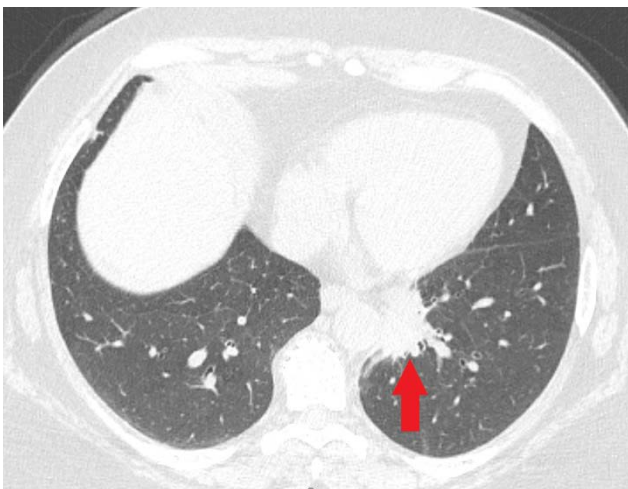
Non-contrast CT of the chest showing spiculated mass-like consolidation of left lower lobe (red arrow)
